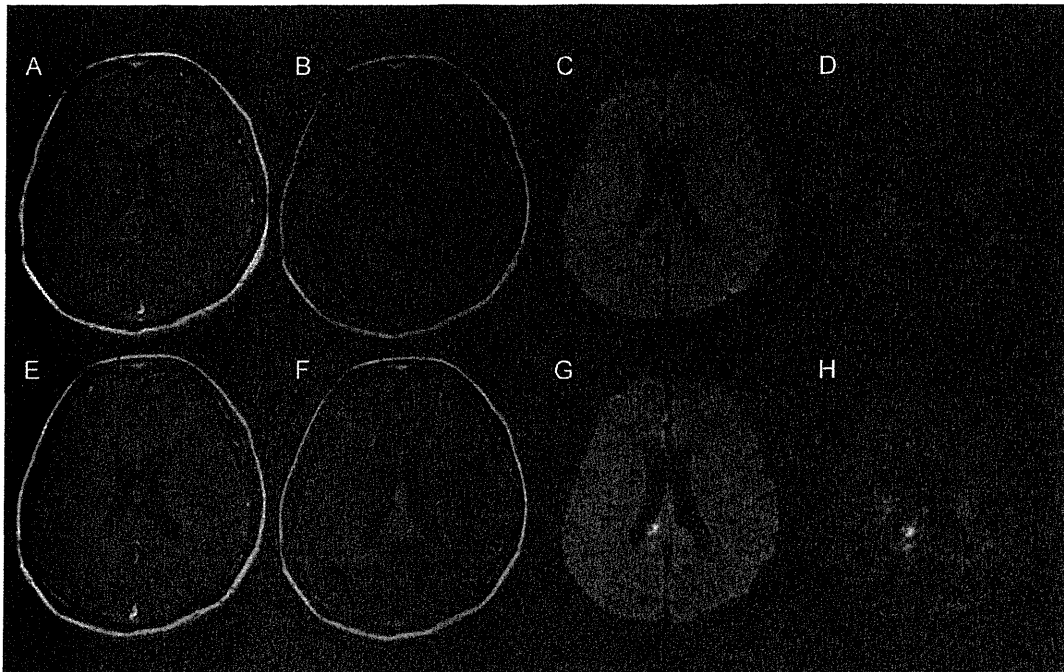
This 47-year-old woman with glioblastoma underwent radical surgery and radiotherapy with concomitant and adjuvant chemotherapy with temozolomide. Gd-enhanced T1-weighted- (A) and FLAIR images (B) and DWI_{1000} (C) and DWI_{4000} (D) were acquired before treatment with bevacizumab. Gd-enhanced T1-weighted images showed a marked decrease in the enhanced lesion (E). On FLAIR images (F) and DWI_{1000} (G) and DWI_{4000} (H) the high-intensity area was increased. She died of tumor recurrence 5 months after the first course of bevacizumab.
